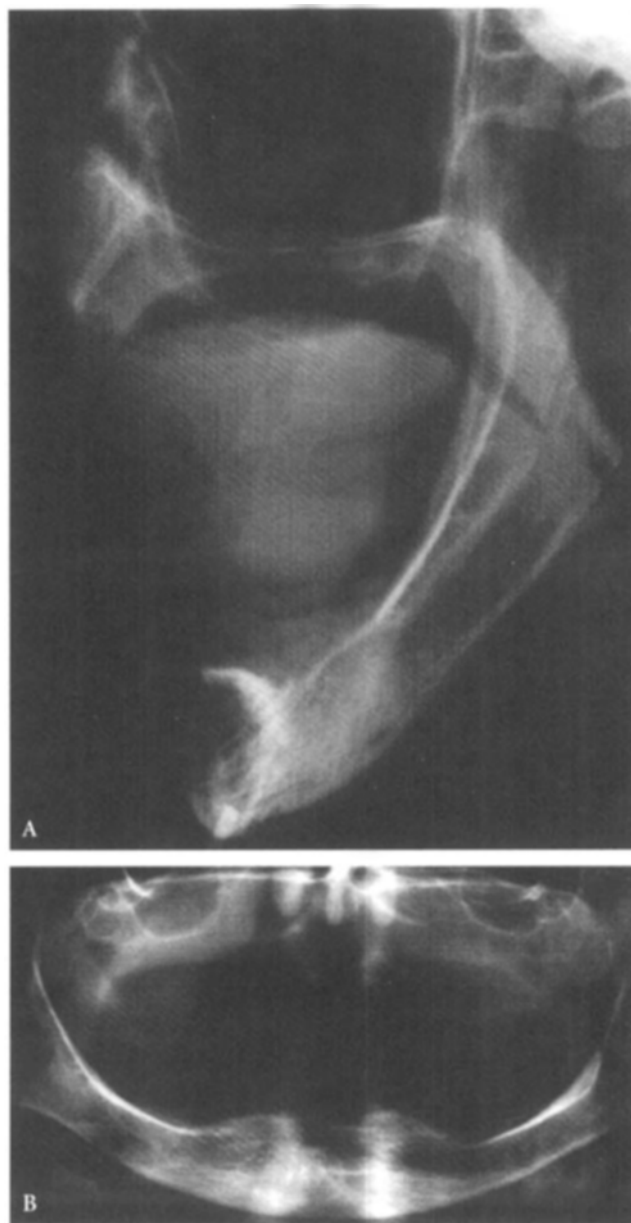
Radiographic views of maxilla and mandible revealing bone quality 4, according to the proposed classification by Lekholm and Zarb.¹⁸
